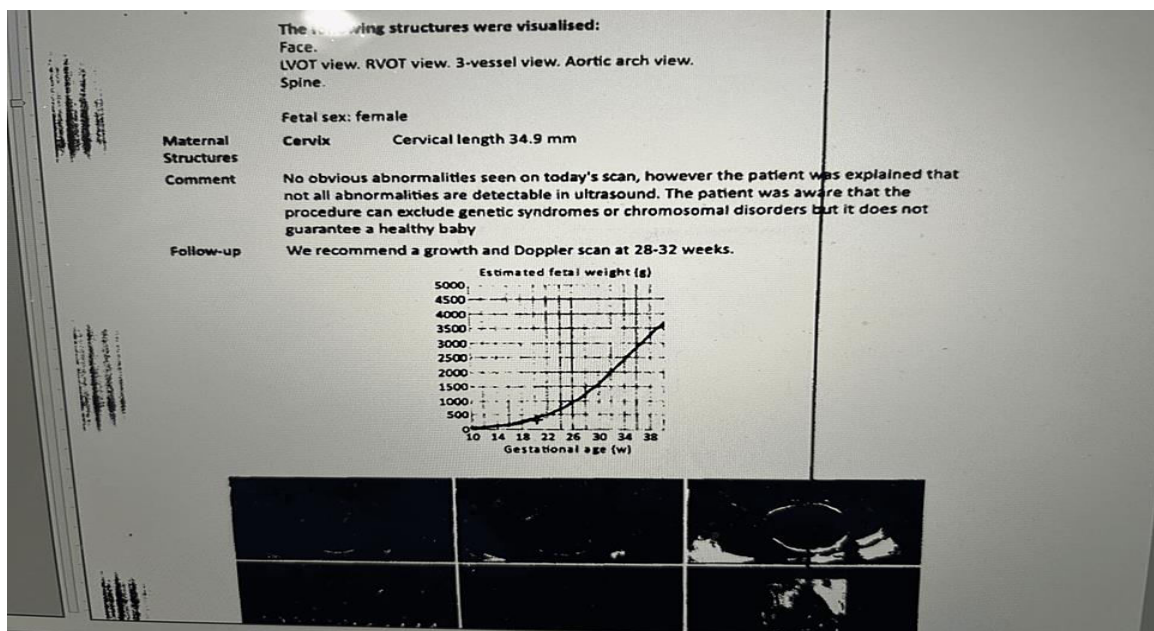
The antenatal ultrasound anomalies scan which demonstrated normal scan.
